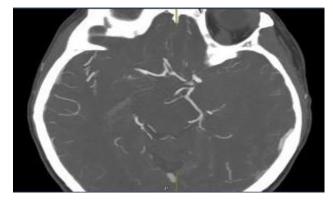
CT angiogram intracranial demonstrating small MCA aneurysm.
